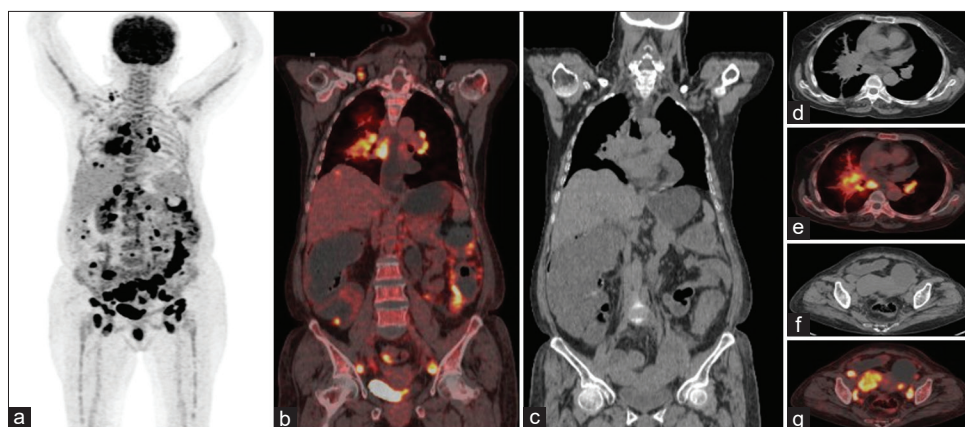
Detection of synchronous malignancies. A 70-year old female patient presented with abdominal swelling for 6 months and enlarged right supraclavicular lymph node; serum CA 125 levels were 1854 U/ml. FNAC from the supraclavicular lymph node was suggestive of a poorly differentiated carcinoma. The patient underwent ^{18}F -FDG PET-CT study; MIP images (a) show multiple foci of increased tracer uptake in the neck, thorax, and the abdomen. Coronal CT and fused PET CT images (b and c) show the increased tracer uptake in the neck, chest, and abdomen localizing to the right supraclavicular lymph node, right lung mass, and mediastinal lymph nodes and bilateral tubo-ovarian masses. Axial CT (d and f) and fused PET-CT images (e and g) showed metabolically active right perihilar mass images, mediastinal lymph nodes, bilateral solid-cystic lesions in bilateral adnexa along with multiple retroperitoneal lymph nodes and a liver lesion (not shown in the images). The patient was diagnosed as synchronous lung and ovarian carcinoma and planned for neoadjuvant chemotherapy. However, the patient expired prior to starting any treatment. PET/CT: Positron emission tomography/computed tomography, FDG: Fluorodeoxyglucose
